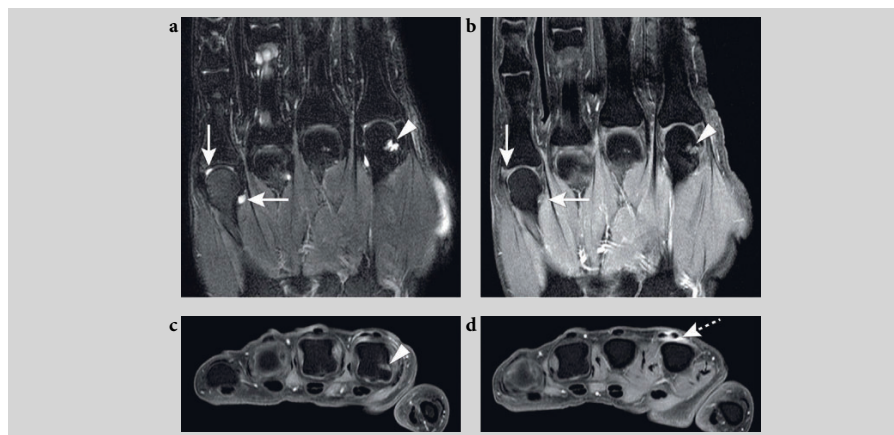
Magnetic resonance images of the left hand in a patient who is positive for anti-citrullinated peptide antibodies with arthralgia but without clinically-detectable arthritis. 1.5T extremity MRI with maximum field of view of 16 cm. Shown are the metacarpal bones 1 to 4 and the proximal phalanges. (a) Coronal T2 TSE fat saturation (fatsat) and (b, c, d) coronal and axial T1 TSE fatsat after intravenous administration of gadolinium. Some fluid is present in the fifth metacarpal phalangeal joint (a; arrows); the lack of enhancement after gadolinium shows there is no synovitis. In the head of metacarpal 2, subchondral cysts are appreciated (a), no enhancement is seen (b, c; arrow heads). However, on the axial images, the enhancement around the extensor tendons of the second finger is consistent with tenosynovitis (d; dotted arrow). In addition on the coronal T2 TSE, partial voluming of fluid, nonenhancing after gadolinium in the soft tissues dorsal to the fourth proximal phalanx is seen.
